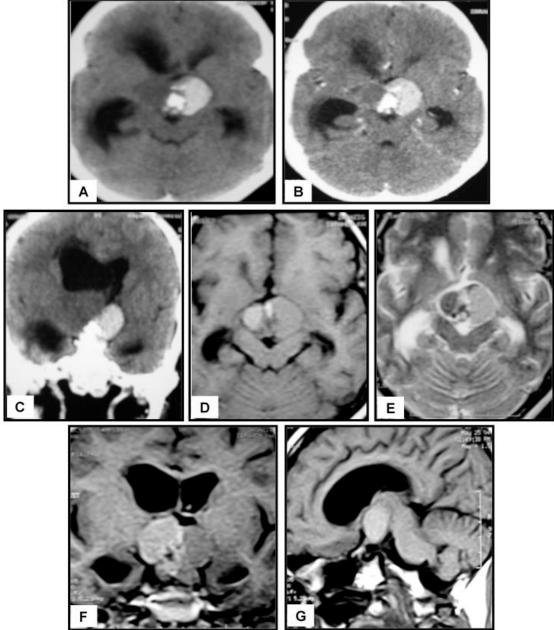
Craniopharyngioma. A 13-year-old male patient presented with diminution of vision and headache. CT Examination: (A) Axial cuts show suprasellar, well-defined mixed attenuation lesion with solid and cystic components. Areas of fresh blood and dense calcification are seen within the lesion. The lesion compresses upon the third ventricle with dilatation of both lateral ventricles. (B) and (C) Post-contrast axial and coronal cuts of the same patient show no enhancement of the lesion. MRI Examination: (D) Axial T1WI of the same patient shows suprasellar well-defined space-occupying lesion of mixed-signal intensity. (E) Axial T2-WI of the same patient shows the mixed-signal intensity of the lesion. (F) and (G) Post-contrast coronal and sagittal T1-WI of the same patient shows no enhancement of the lesion. The lesion is seen compressing upon optic chiasm and third ventricle with dilatation of both lateral ventricles.
